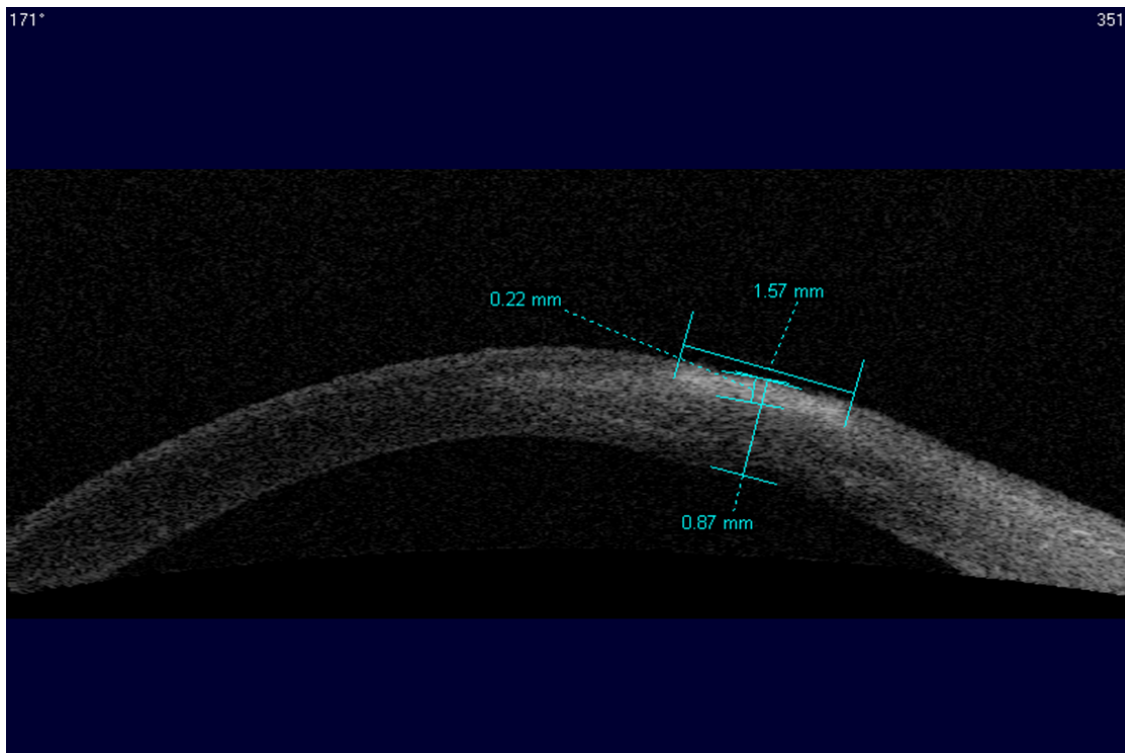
AS-OCT measurement protocol in bacterial keratitis. The infiltrate thickness (IT) and infiltrate width (IW) were measured with placement of the callipers at the axial and transverse borders of the hyper-reflective infiltrate. Corneal thickness (CT) was measured at the infiltrate centre with calliper placement on the axial borders of the cornea.
